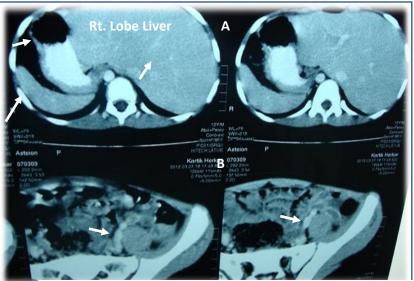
CT abdomen shows a. spleen and stomach on right side and right lobe of liver on left side (SIT). b. inflamed left sided appendix
